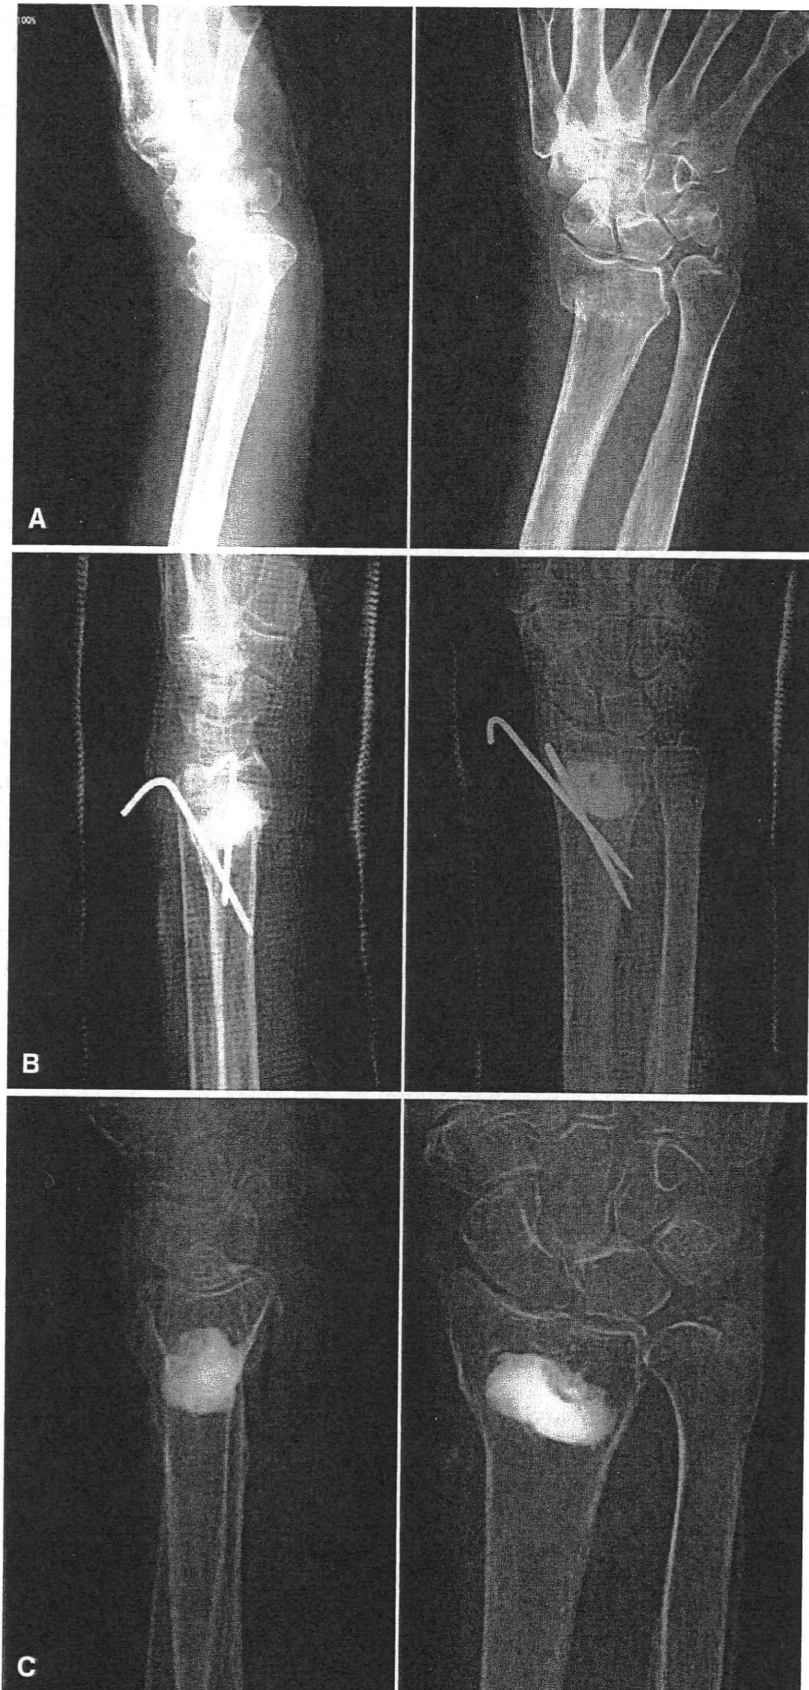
a Presurgical radiographs of the wrist show a typical Colles' fracture in an elderly women with osteoporosis. b Postoperative radiographs show good reduction without CPC leakage. Radial inclination was 27°; ulnar variance was 1 mm; and volar tilt was 2°. c Radiographs at 15 months after surgery show minimal radiological change. Radial inclination was 25°; ulnar variance was 1 mm; and volar tilt was 2°
